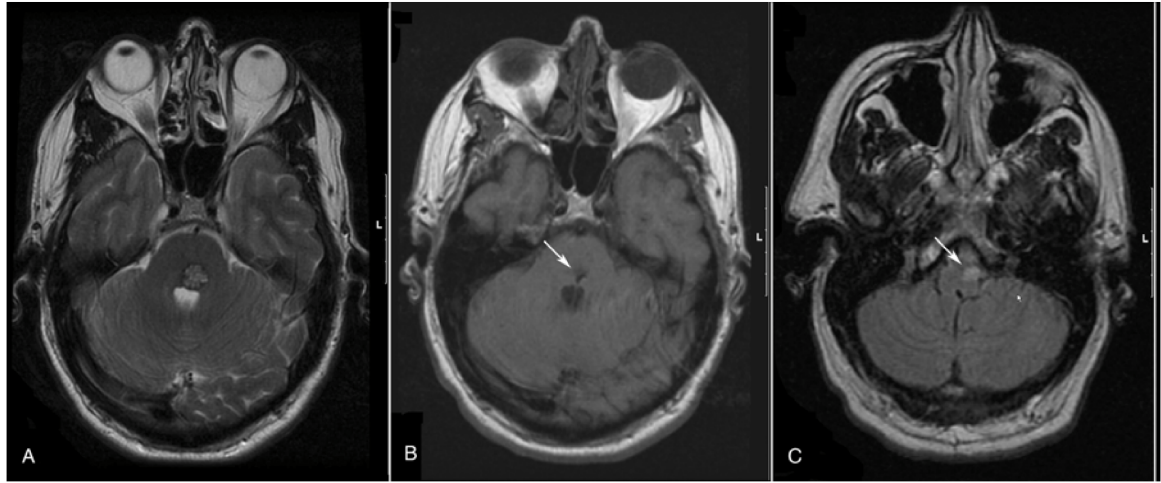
MR imaging scans of Patient 1. (A) Axial T2-weighted, preoperative MR image demonstrates the location of the cavernous malformation in the left dorsal pons. (B) Axial, unenhanced T1-weighted MR image obtained four months following resection demonstrates the unremarkable postoperative changes at the operative site (arrow). (C) Postoperative axial FLAIR MR image shows increased signal intensity in the left lateral medulla with an enlarged olivary nucleus (arrow) compared to the contralateral side; left unilateral HOD.
